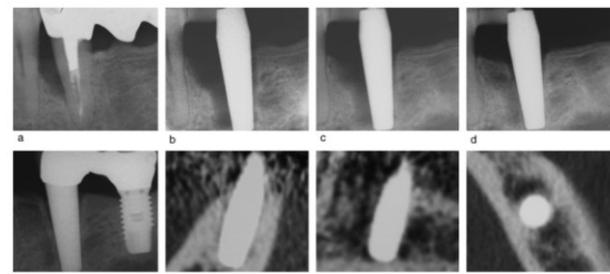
Ligaplant radiography. (a) Before surgery, root fracture in tooth #34 plus bone defect mesially (left) to the fractured root. (b) Same location immediately after ligaplant implantation. (c) Partial bone regeneration after 24 weeks. (d) After 24 months, note the almost complete replenishment of the major defect. (e) Forty-two months; the periodontium has partially restructured with a fairly regular desmodontal space and reinforced bony demarcation around this space. (f–h) Tomography analysis after 24 months; frontal view (f), side view (g), top view (h). The ligaplant is surrounded by bone trabeculae. Ligaplant dimensions: 15mm in length, 5–7mm in width.
